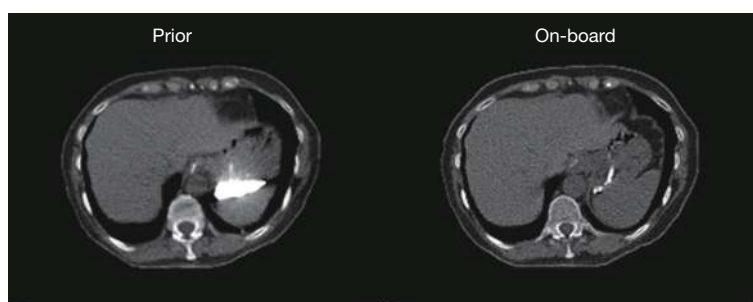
Left is the 1st set CT used as prior image and right is the 2nd set CT used to generate digitally reconstructed radiography (DRR) for reconstruction.
